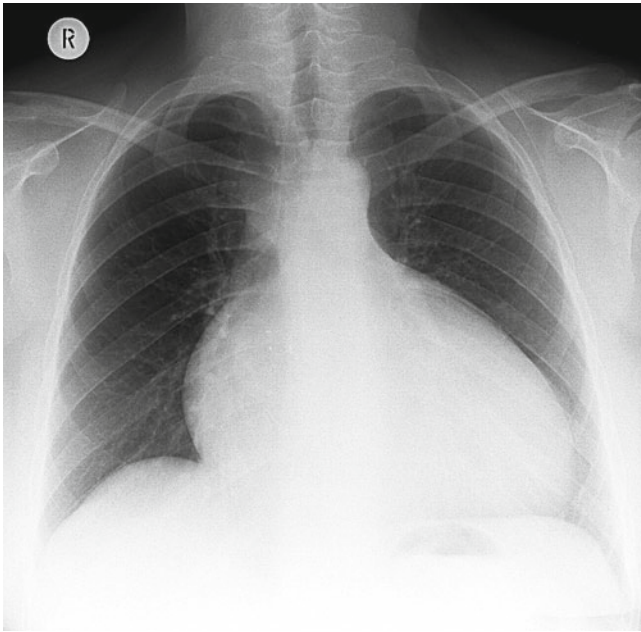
Chest X-ray of a patient with Ebstein's anomaly of the tricuspid valve. Note marked cardiomegaly with globular shape of the cardiac silhouette, small aortic knuckle, and reduced pulmonary vascular markings
